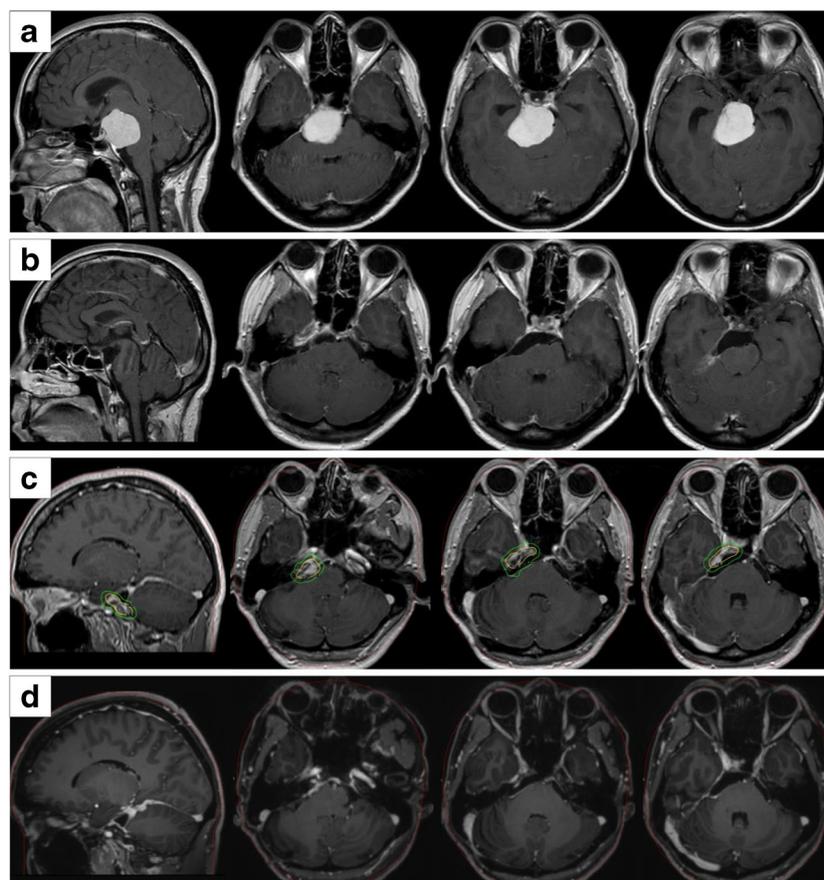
An example of complementary treatment is provided. a Sagittal and axial contrast-enhanced (CE) magnetic resonance images (MRI) showing a large petroclival meningioma before surgical resection. b Sagittal and axial CE early postoperative MRI, no significant/definite residual tumor was identifiable; good facial nerve function (House-Brackman grade II) and motility of all ocular movements was preserved; functional hearing was already lost at the time of presentation. c At subsequent FU, a progressive thickening of the dural attachment was observed; Gamma Knife radiosurgery (GKRS) treatment was performed 5 years after surgery on the enlarging residual remnants of the tumor. d Sagittal and axial CE MRI FU acquired 3 years after GKRS treatment showing regression of the treated lesion without any additional morbidity.
